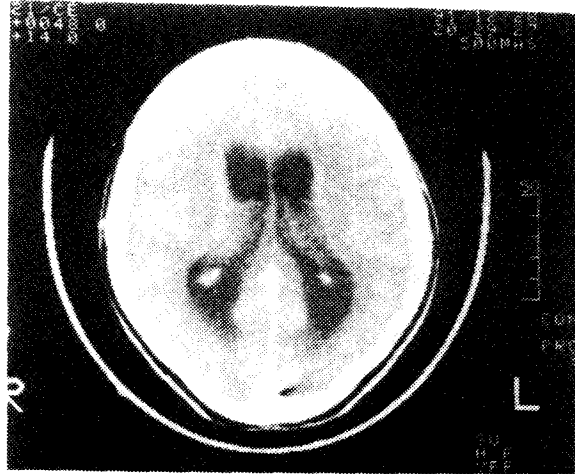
Post contrast CT head scan showing moderate hydrocephalic changes.
